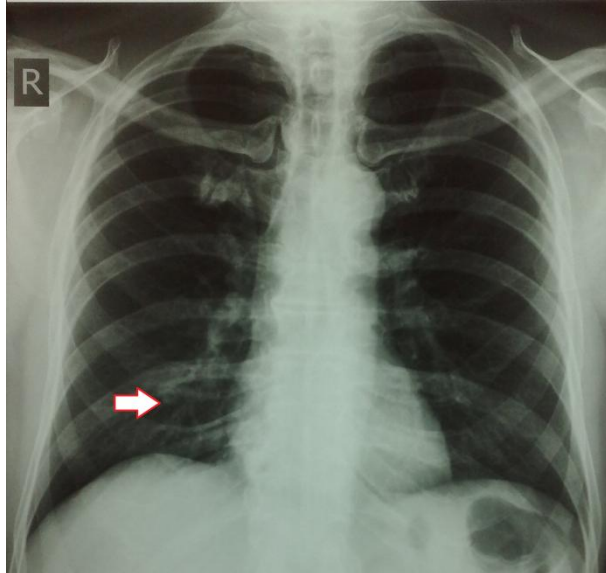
Chest x-ray showing the calcified nodular lesion in the right mid-zone.
